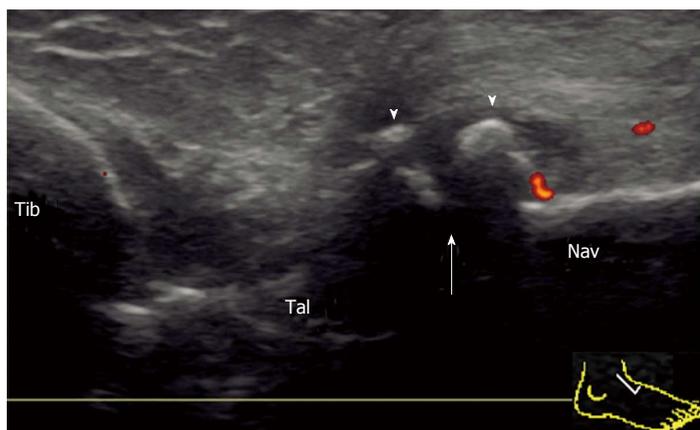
Deformity of the talonavicular joint in rheumatoid arthritis. Longitudinal power Doppler sonogram of the dorsal aspect of the TNJ shows joint space narrowing (arrow) and osteophyte formation (arrowhead) with minimum flow signal adjacent to an osteophyte. TNJ: Talonavicular joint; Tib: Tibia; Tal: Talus; Nav: Navicular.
